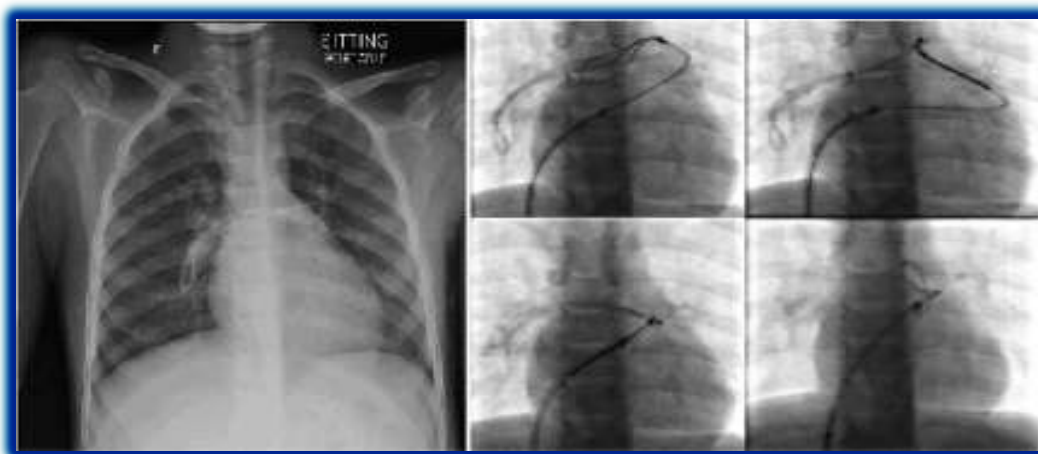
(b) Chest X-ray and fluoroscopy image
